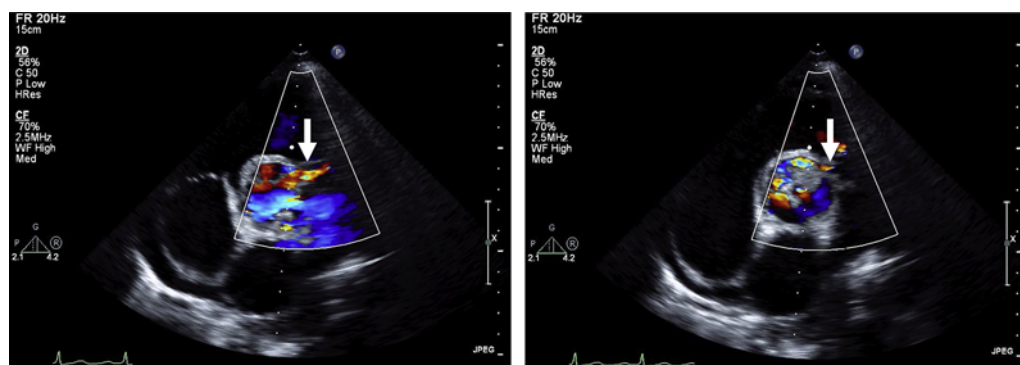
Parasternal short-axis views in systole (left) and diastole (right) showing fistula flow from the aortic root to the pulmonary artery throughout the cardiac cycle (white arrows).
